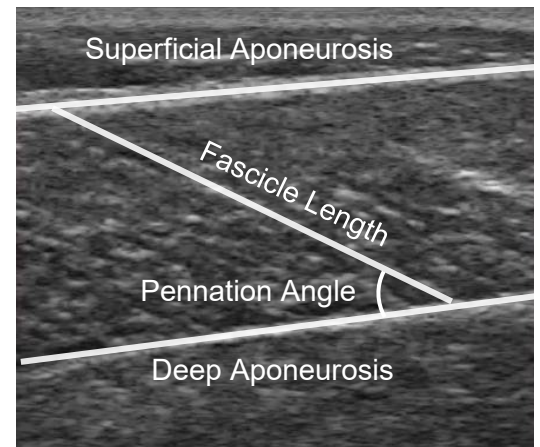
(1 column). Resting muscle architecture was measured from an ultrasound frame captured at 16° plantar flexion. An examiner identified the two aponeuroses as well as a fascicle within the frame, each of which was approximated as a straight line. Pennation angle was calculated as the angle between the fascicle and the deep aponeurosis and muscle thickness was calculated as the sine of the pennation angle times the length of the fascicle.
